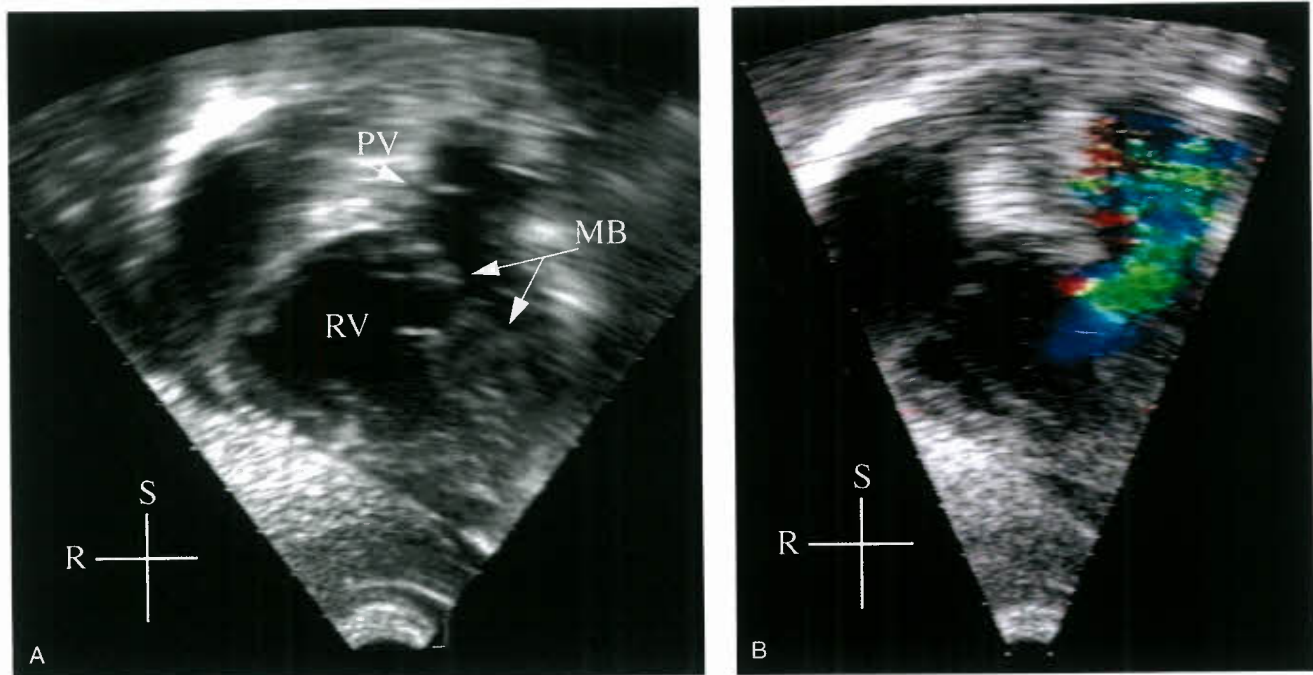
A: Subcostal view of the RV from a patient with double-chambered RV. The anomalous muscle bundle (MB) courses obliquely across the RV. B: Color-flow Doppler through the obstructing MB has a mosaic pattern consistent with high-velocity flow. PV, pulmonary valve; R, right; S, superior.
